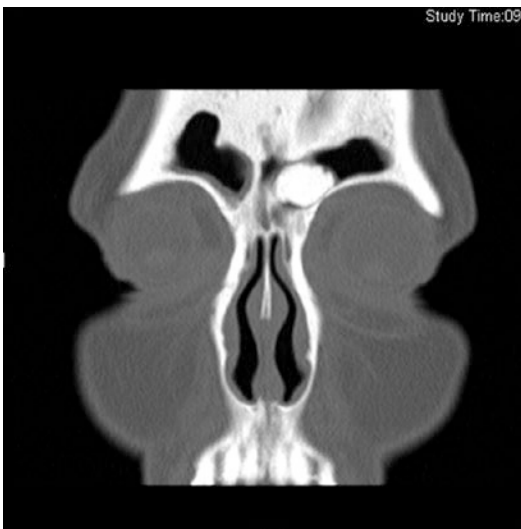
Coronal CT of the paranasal sinuses revealing a left frontal sinus osteoma with good aeration of the frontal sinus
